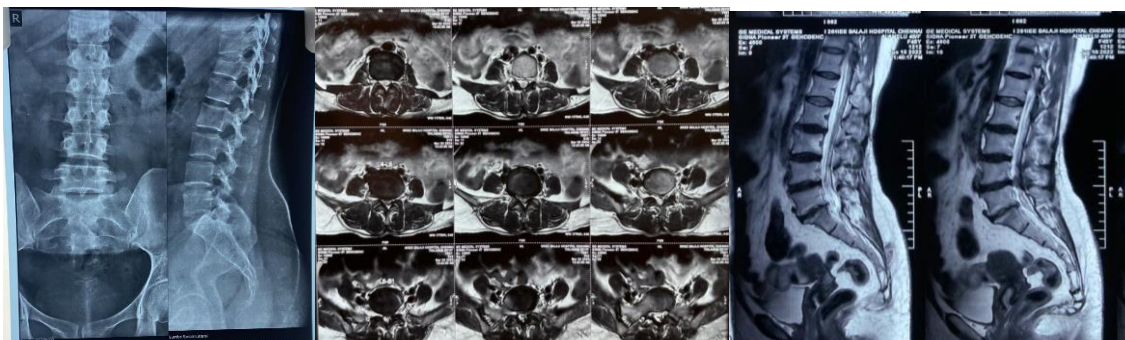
4B, and 4C PREOPERATIVE XRAY AND MRI OF LUMBOSACRAL SPINE
